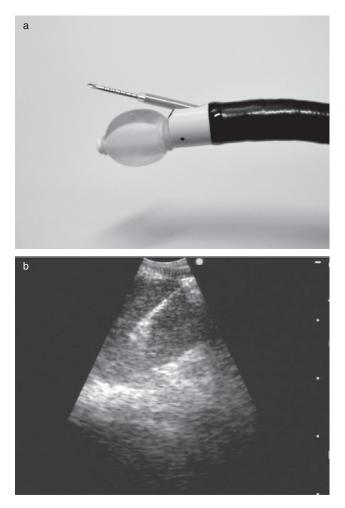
(a) Tip of the ultrasonic puncture bronchoscope (CP-EBUS; BF-UC260FW) with the linear curved-array ultrasonic transducer. The balloon attached to the tip of the bronchoscope is inflated with normal saline solution, and a dedicated transbronchial needle aspiration (TBNA) needle is inserted through the working channel. (b) Real-time CP-EBUS-guided TBNA was carried out. A 22-G needle is seen within the lymph node.
